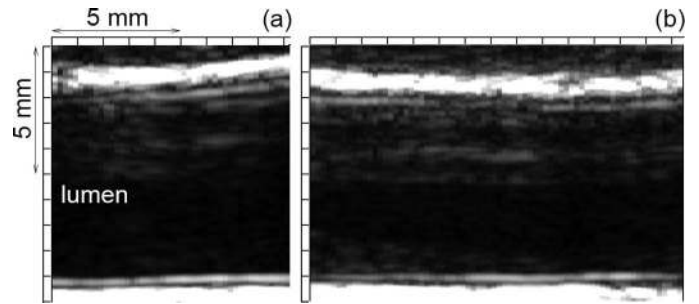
Longitudinal B-mode image of the right common carotid artery of a 33-year-old male obtained (a) by conventional linear scanning and (b) by ultrasonic beams formed with beam angles ϕ of 90 degrees based on parallel beamforming.
